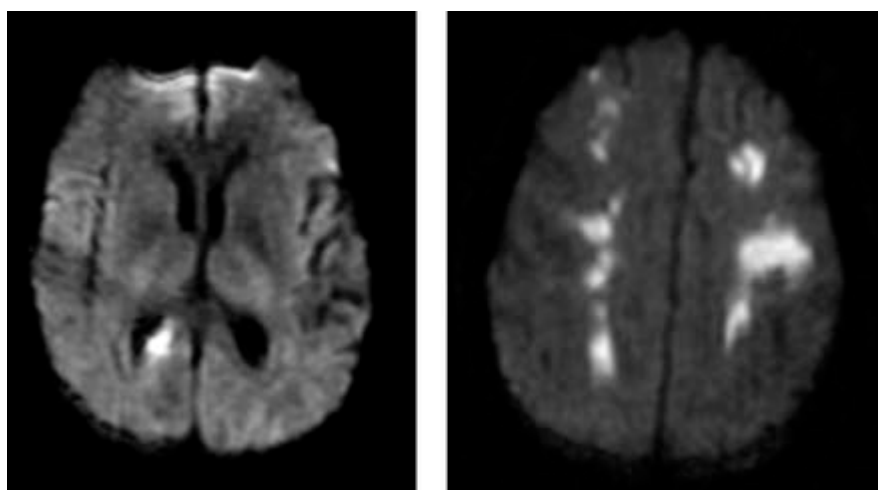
20 Two MRI (DWI) images of 2 patients with postoperative infarcts: on (Left) Patient with acute territorial infarct (Right) Acute bilateral watershed stroke (Gottesman et al, 2006)
